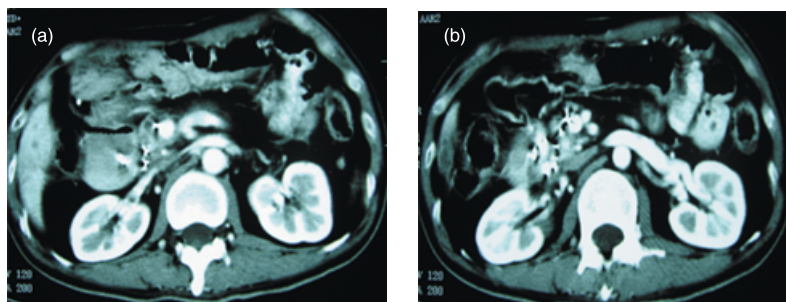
Computed tomography scan in patient 3 (a) before treatment, (b) three months after treatment.
